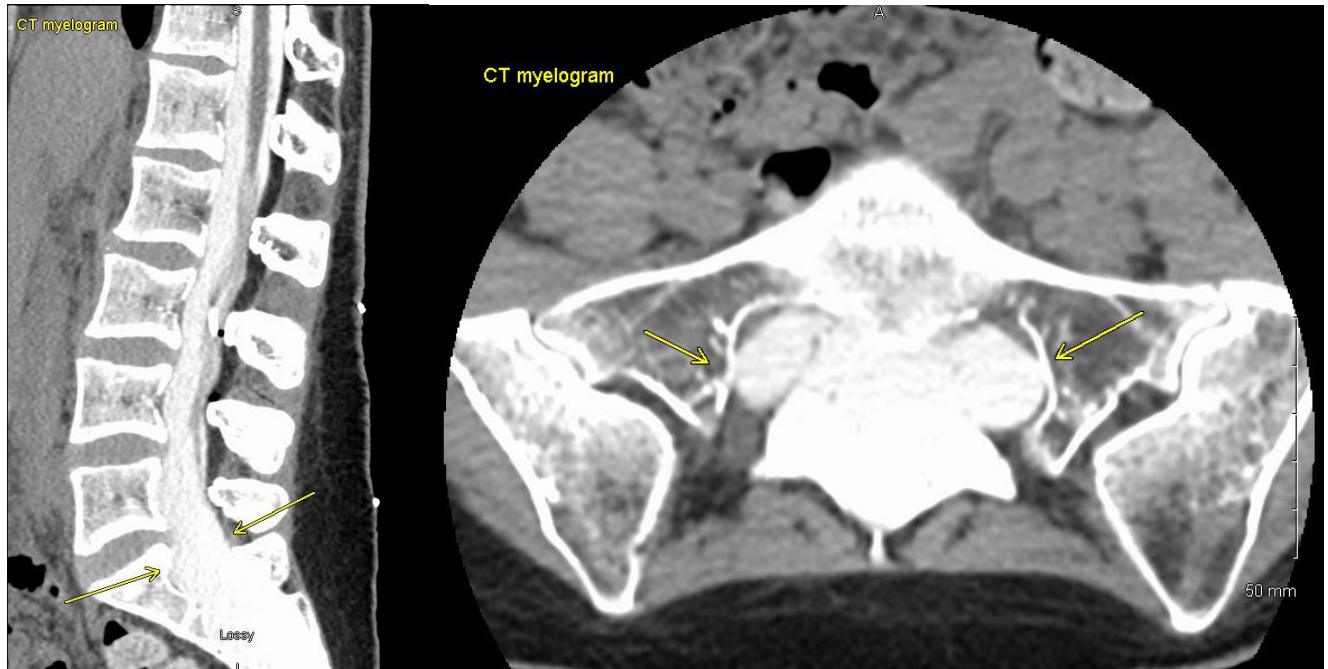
CT myelogram demonstrating dural ectasia in sacral region.
